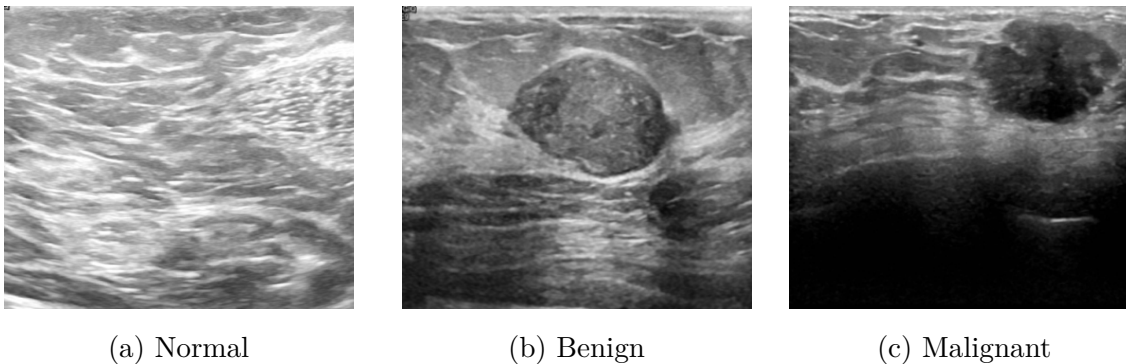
Representative samples of breast ultrasound images: normal, benign, and malignant classifications.
